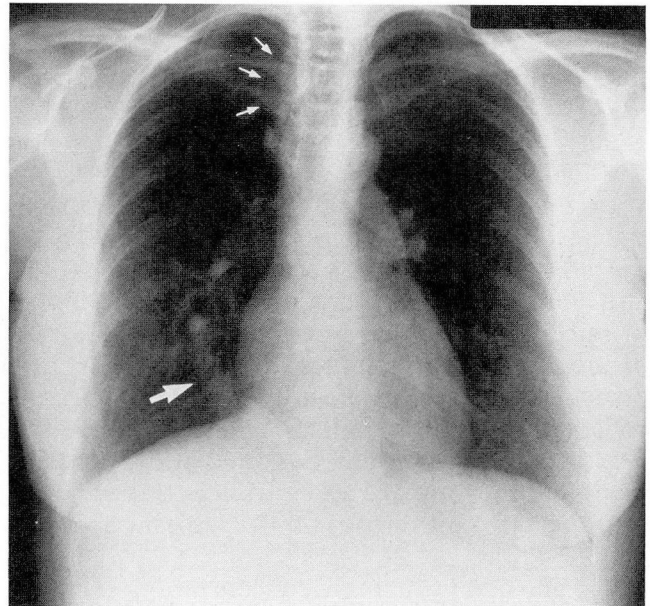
Preoperative chest radiograph demonstrating the scimitar sign (large arrow). Associated azygous lobe is also present (small arrows).
